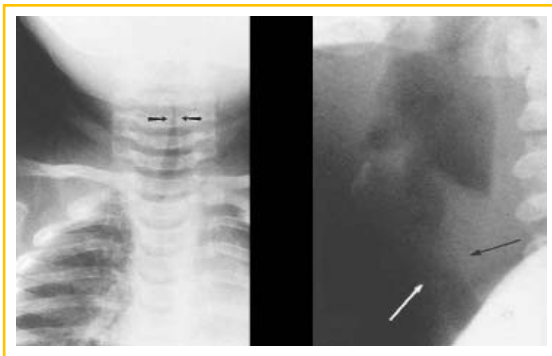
This radiograph demonstrates steeplechase narrowing of the trachea in a young child with croup. See arrow.
